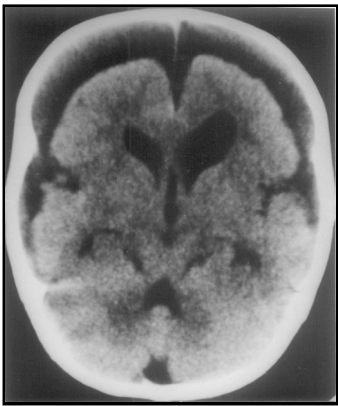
CT head showing bihemispheric subdural fluid collection following head trauma which required evaluation. He had no recurrence in follow up.
